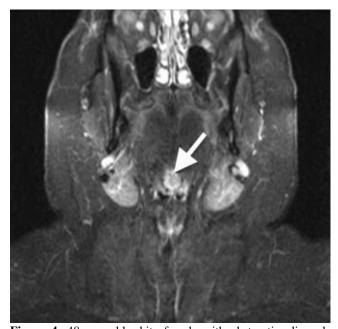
48-year-old white female with obstructive lingual thyroid. Follow up MRI (approximately 25 months after therapy) showing the post-treatment lingual thyroid. Previously described mass now measures $1.8 \times 1.5 \times 1.6$ cm. T1 weighted spin echo images performed with fat saturation in coronal plane after i.v. administration of gadolinium.
